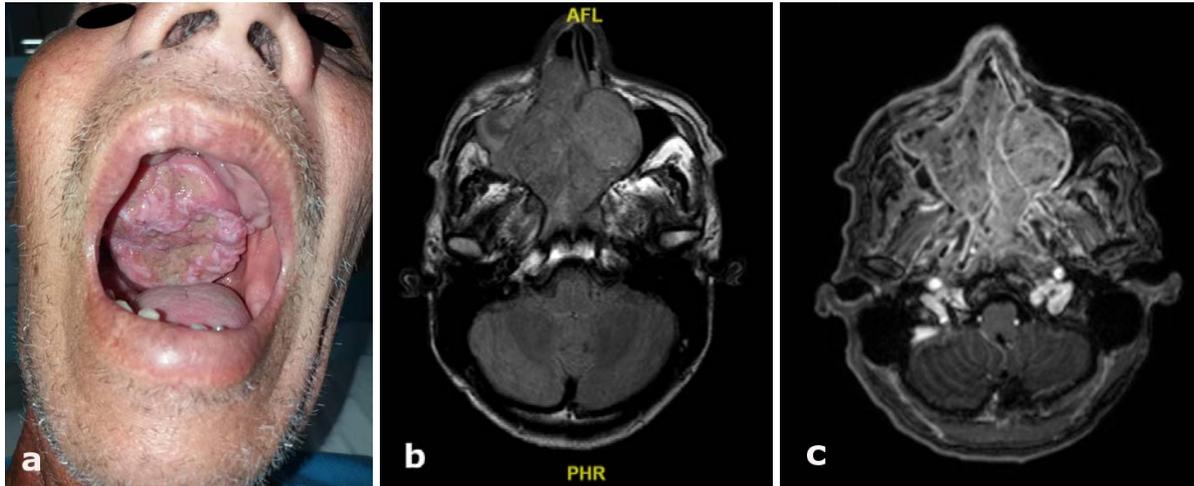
(a) A large fungating ulcerated mass of the hard palate extending posteriorly. (b) Axial view of MRI of brain shows there is presence of large multilobulated mass with hypo-to-isointense signal on T1, (c) heterogenous hyperintense signal on T2 and heterogeneously enhanced post contrast. The mass extends anterosuperiorly to abut the frontal sinus and involve the right maxillary sinus, anterior ethmoid air cells, right posterior ethmoid air cells, sphenoid sinus and bilateral nasal cavities.
